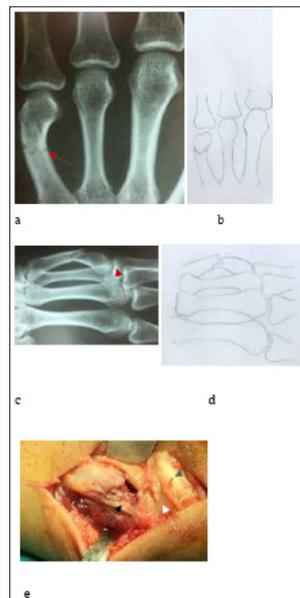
Type II fracture, x-Rays (red arrow) AP (a,b), Oblique (c,d), surgical evidence (black arrow fracture, white arrow neck 5th metacarpal, grey arrow extensor digit minimi) (e).
